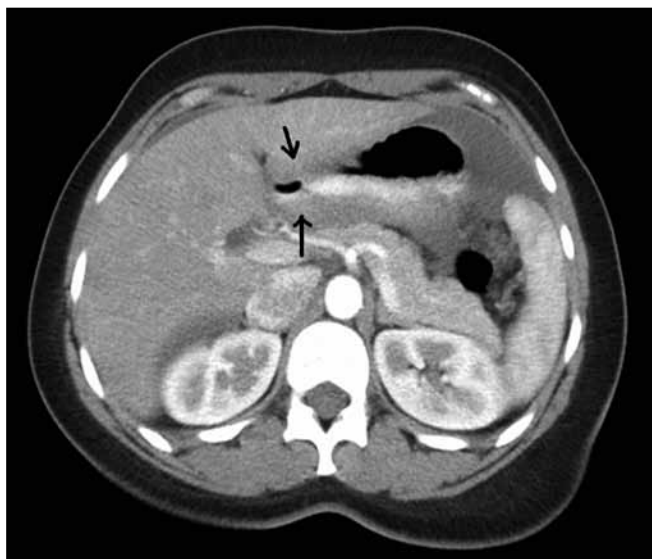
A computed tomographic (CT) scan of the abdomen showing thickening of the gastric antrum (arrows).
